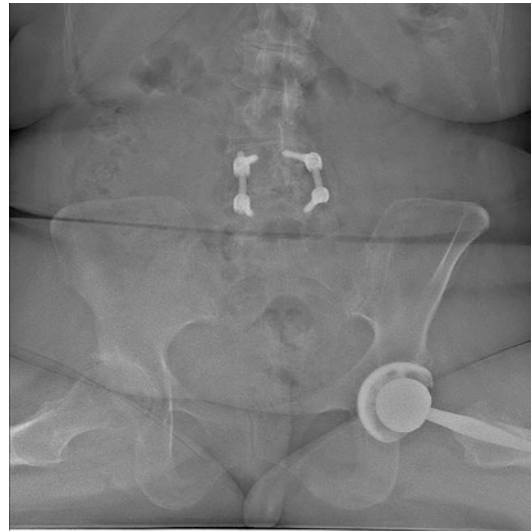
Seated AP EOS preoperative radiographs demonstrate resolution of pelvic obliquity in the seated position confirming that the pelvic obliquity is flexible
